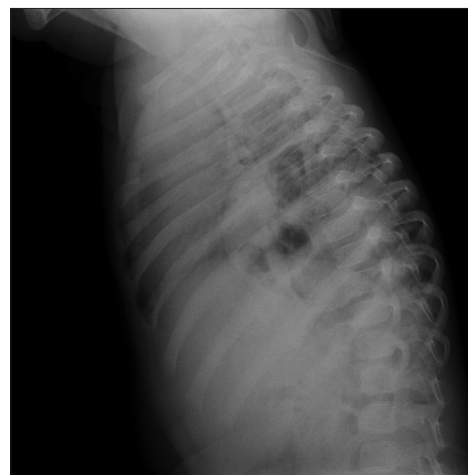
Lateral X-ray of chest shows intestinal loops in posterior aspect of hemithorax
